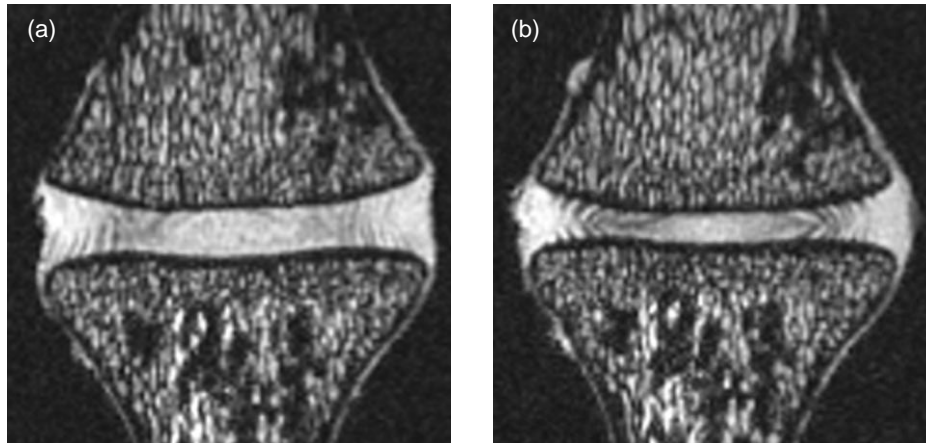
Images from the anterior region of S1 for the MRI-P (a) and MRI-L (b) scans.
